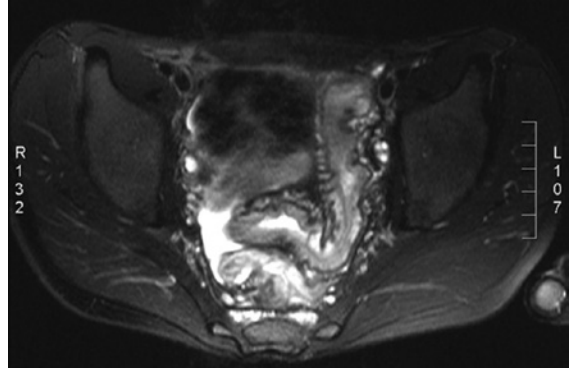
MRI is used to assess the small bowel affected by Crohn disease that is not accessible to endoscopy.
